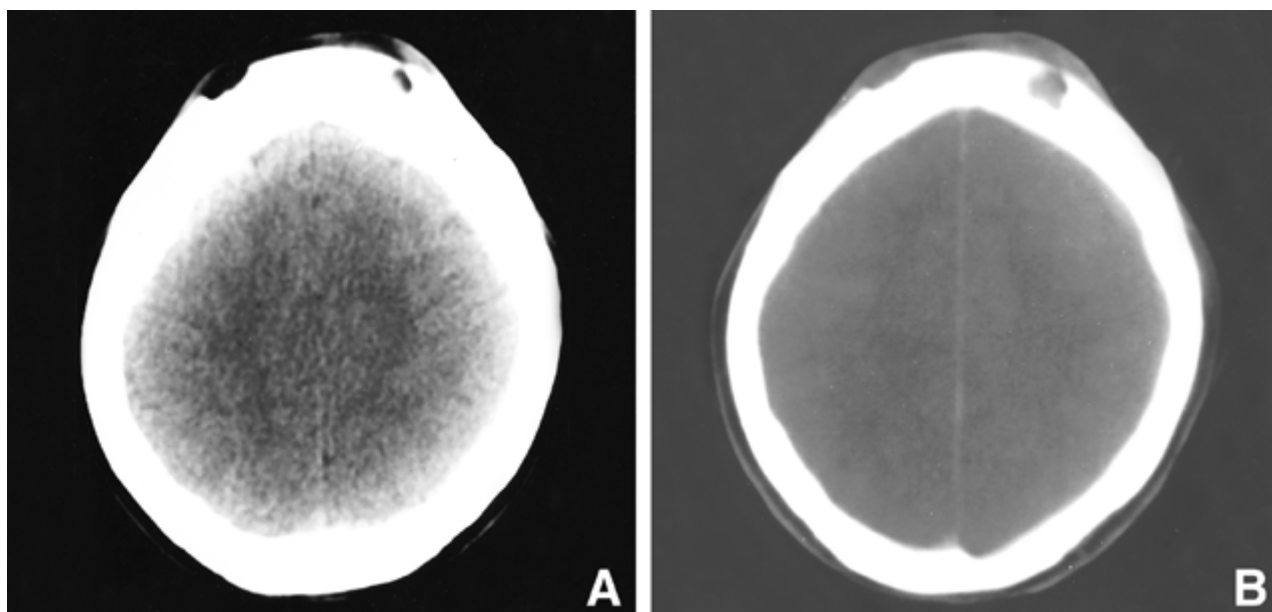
Brain CT scan demonstrated multiple osteolytic lesions at the diploic space (A), which is more well-delineated at the bone window image (B).
